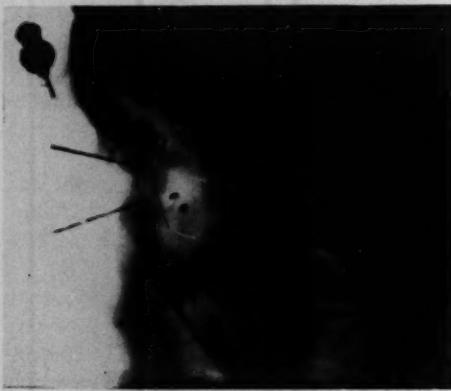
(Worst and Otter). Construction of the center of rotation after Ambos. Two superimposed exposures are taken on one roentgen film. By lengthening the cannula backward they will intersect in the center of rotation. The radius of the eye is equal to the distance from the center of rotation to the end of the limbal ring.
